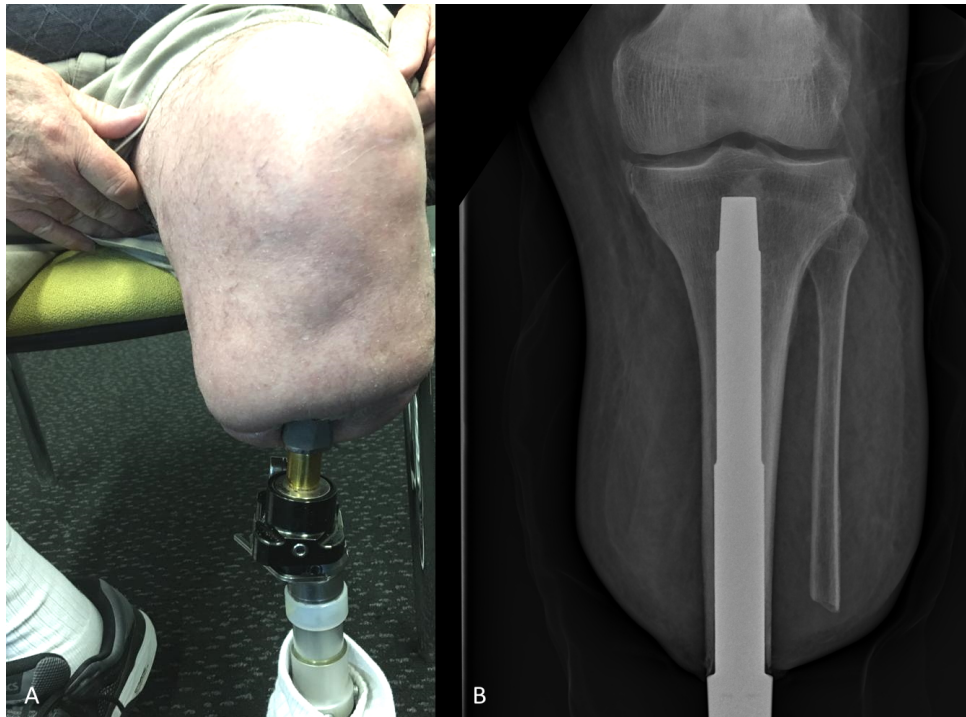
(A) Clinical photograph and (B) radiograph of patient with a transtibial osseointegration.
